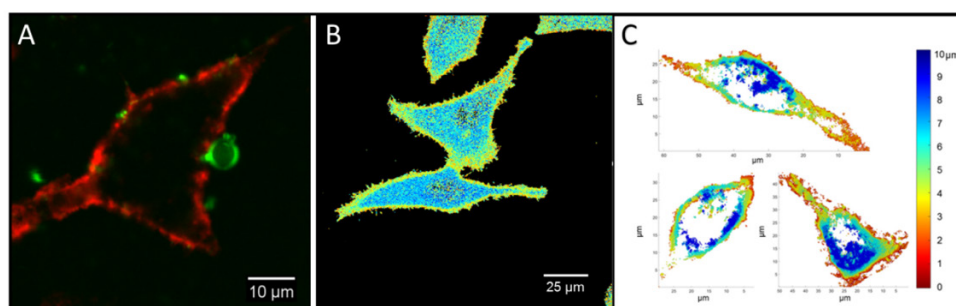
(a) DSPC-PEG40S microbubble labelled with DiI, a lipid-mimetic fluorescent probe (green) attached to an A-549 cell membrane (CellMask, red). (b) Map of the lipid order of cells quantified by generalised polarization from spectral imaging with polarity-sensitive probe, C-Laurdan. Lipid order increases from blue to red. (c) Maps of the 3D colocalization of DiI with A-549 cell membranes following ultrasound exposure of DiI-loaded DSPC-PEG40S microbubbles.
